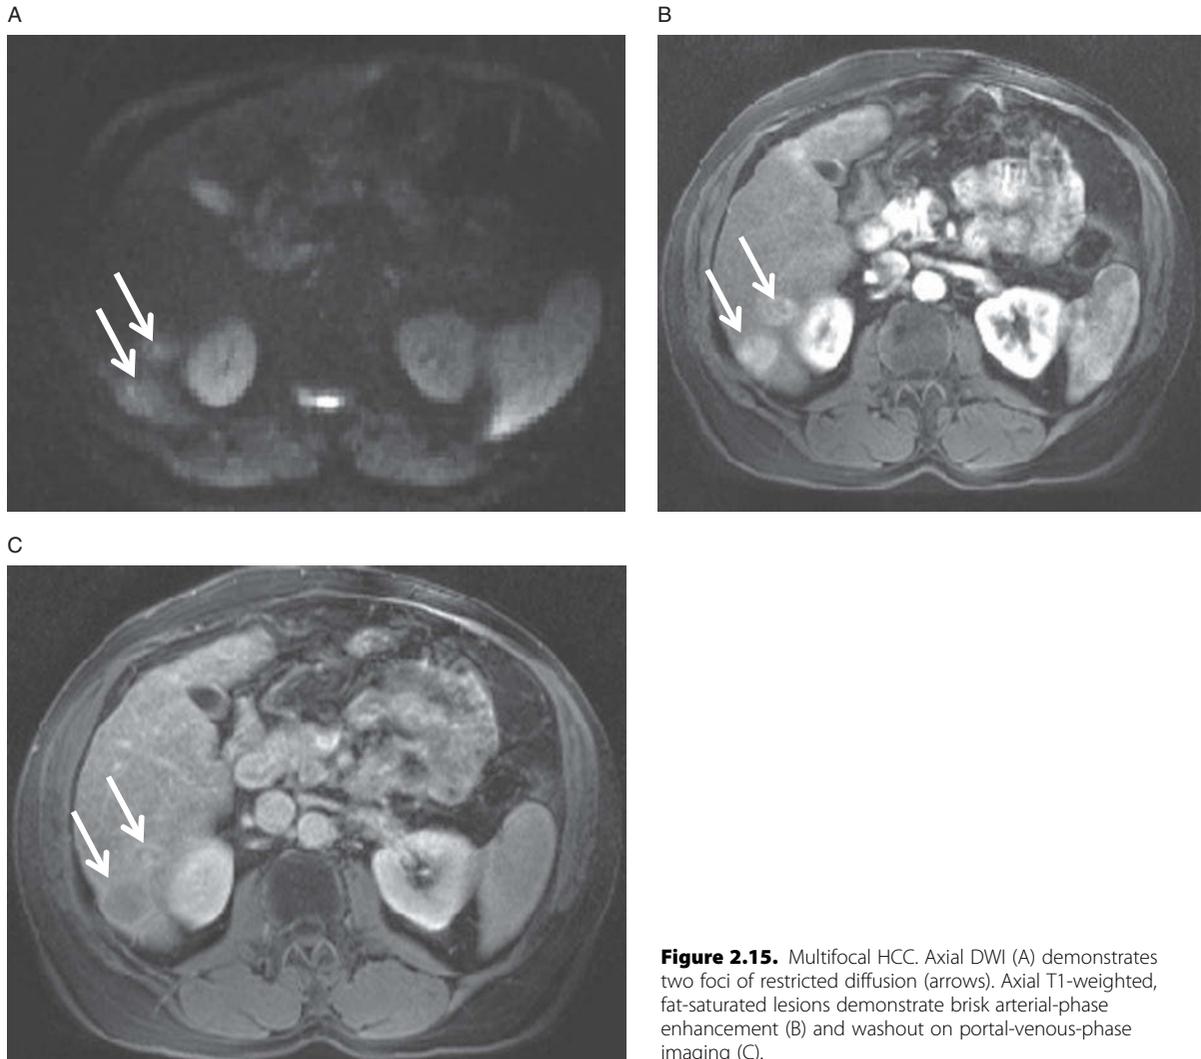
Multifocal HCC. Axial DWI (A) demonstrates two foci of restricted diffusion (arrows). Axial T1-weighted, fat-saturated lesions demonstrate brisk arterial-phase enhancement (B) and washout on portal-venous-phase imaging (C).
